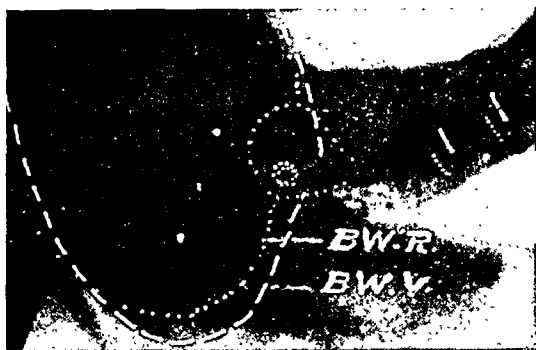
Radiograph after my operation on a bladder and urethra, in the "voiding" state (B.W.V.) superimposed upon the same bladder and urethra in the "relaxing" state (B.W.R.). The "voiding" state is almost identical with the "relaxing" state. The nearer the "voiding" state approaches the "relaxing" state, the more efficient the continence will be.
